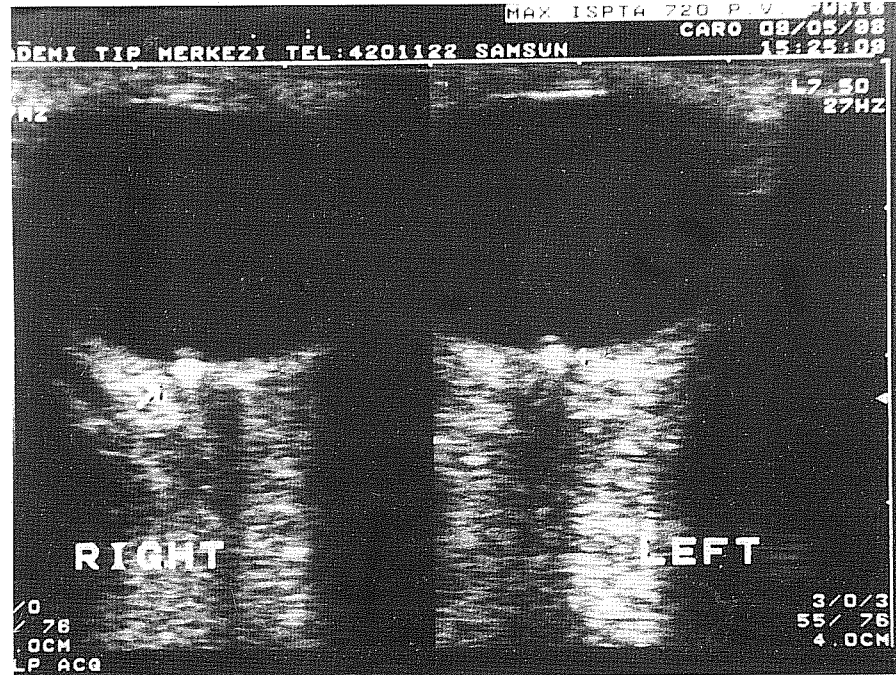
B-Scan ultrasonography. Hyperdense image and smooth elevation are evident in both optic discs.
